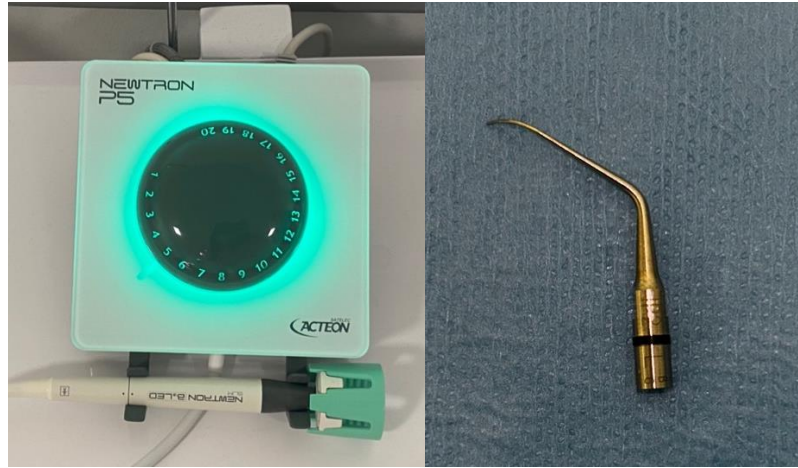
The ultrasonic scaler (NUS) device and IP2L tip
